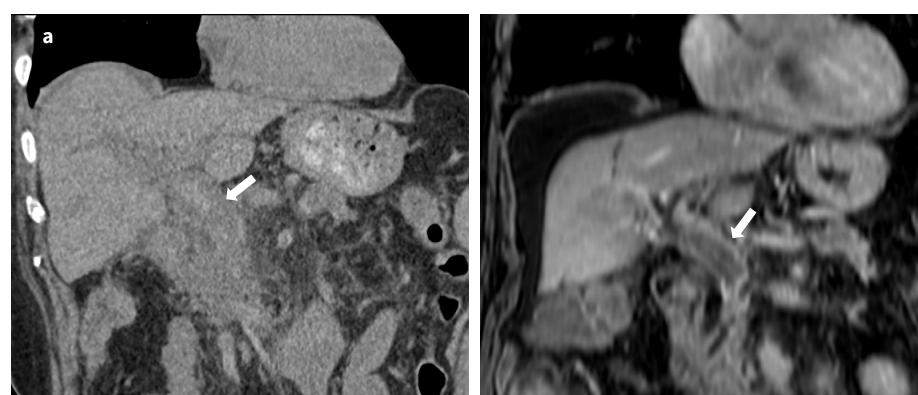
Acute portal vein thrombosis. a | Non-contrast CT imaging of a patient with acute abdominal pain and renal function impairment in the coronal plane shows peri-hepatic hilar infiltration and a spontaneously hyperdense portal vein (arrow), suggestive of the presence of an intravascular clot. b | T1-weighted contrast enhancement MR confirms acute portal vein thrombosis (arrow).
